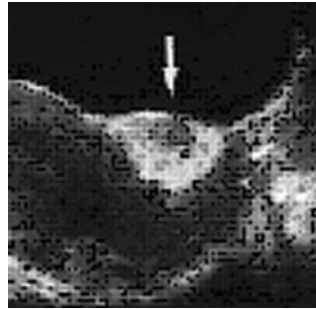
Unusual Sonographic appearance of the Leiomyoma. Hyperechoic mass suggestive of Hyaline, Fatty or Red degeneration.
